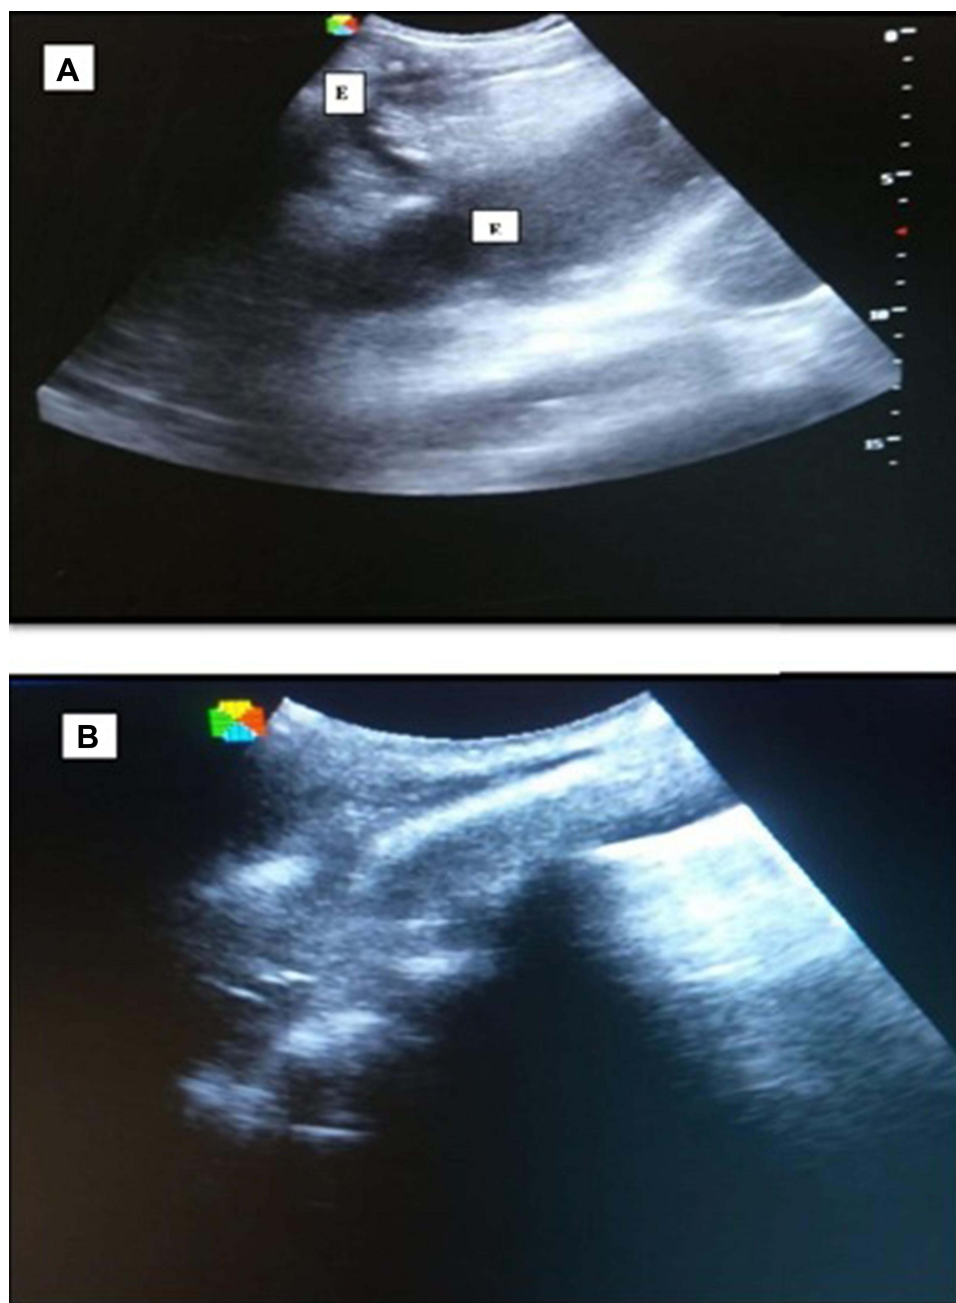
Thoracic ultrasound: (A) complex pleural effusion with loculation; (B) homogeneous effusion with septation after evacuation trial.
